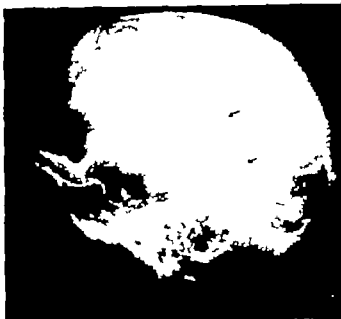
Roentgenogram of Case 1, R. R., showing intracerebral shadows suggestive of vascular calcification.
